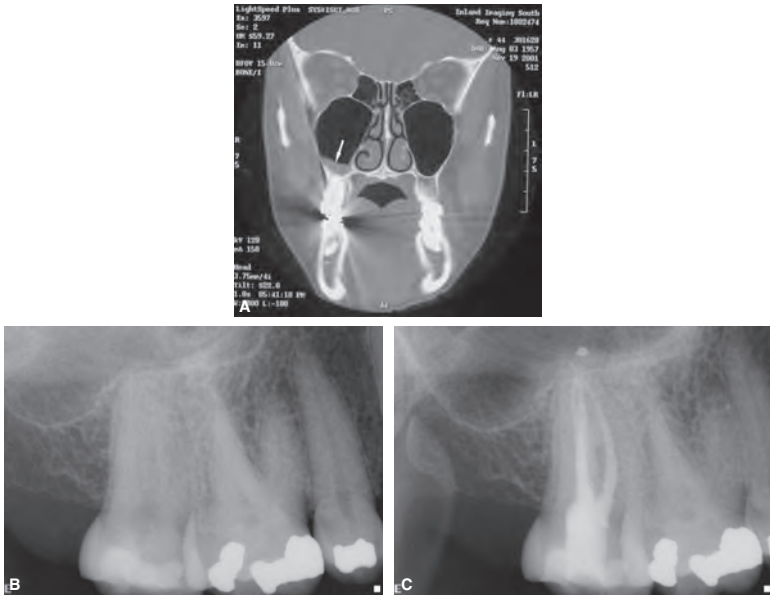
Maxillary sinusitis of dental origin (MSDO). A, Coronal CT image of a patient diagnosed with right maxillary sinusitis, (*arrow*). B, Periapical radiograph shows no evidence of periapical radiolucency; however, the right maxillary sinus appears clouded. Clinical tests reveal the pulp in tooth #2 to be necrotic. C, Follow-up radiograph taken 4 weeks after RCT in tooth #2 with patient reporting resolution of sinusitis symptoms. The sinus appears less clouded than preoperatively on the periapical radiograph.
